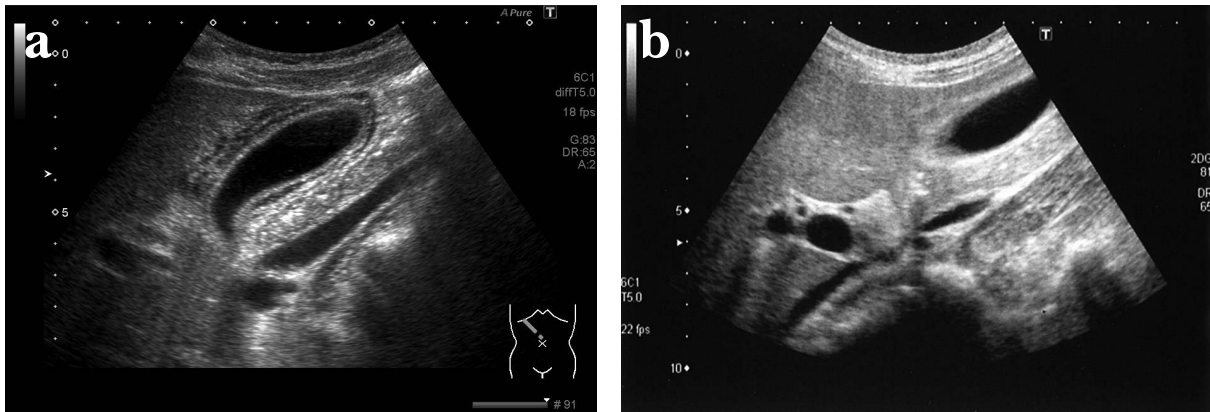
Abdominal ultrasonography on admission (4a) showing 7 mm gallbladder wall thickening and double wall sign, which significantly improved by Day 10 (4b).
